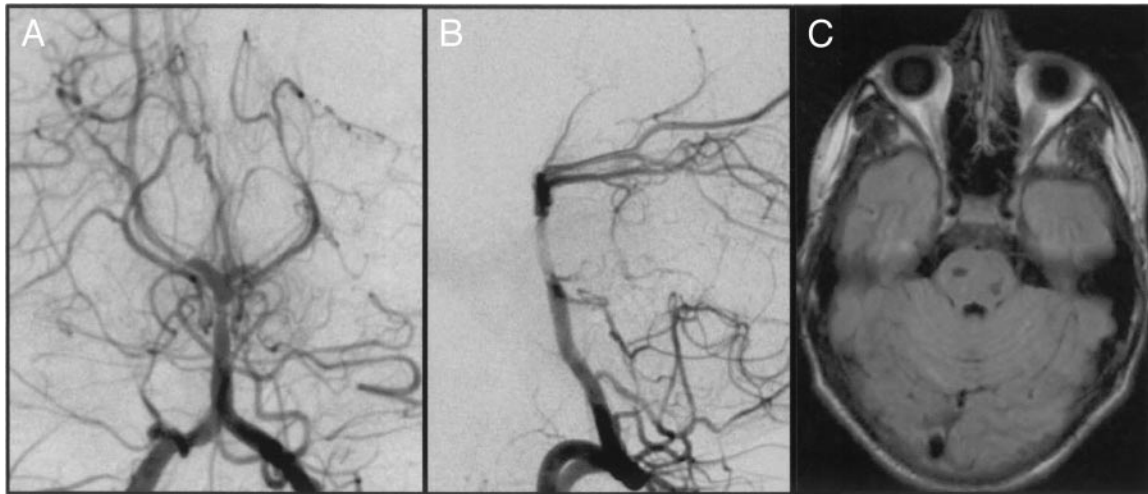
Follow-up imaging. A and B, Angiography at the end of the endovascular procedure demonstrates persistent stenosis of the basilar artery but excellent anterograde filling. C, Follow-up T1-weighted axial MR scan shows infarcted regions as cystic encephalomalacia.
